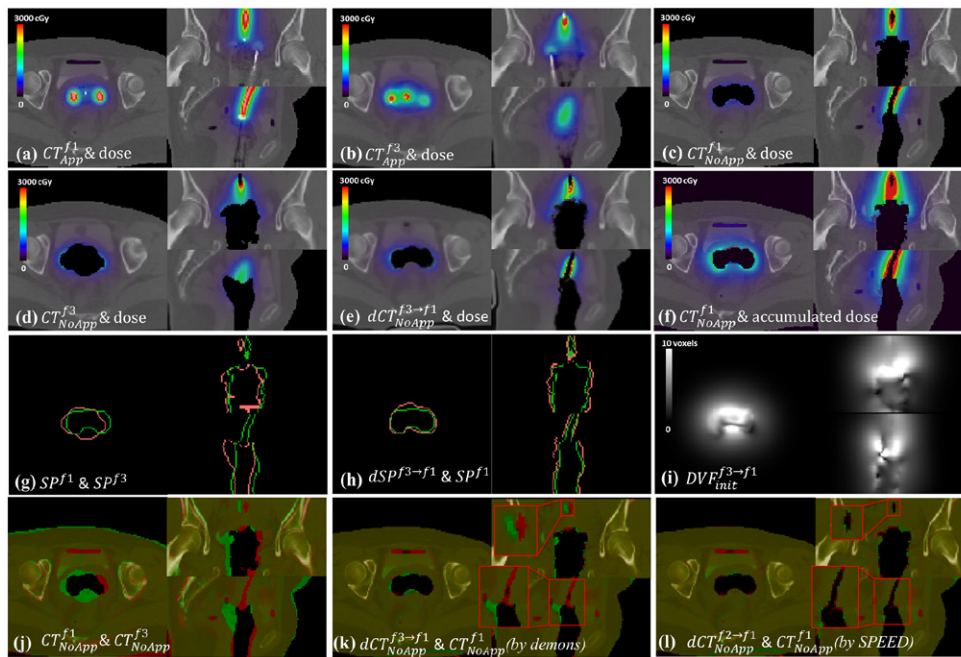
DIR results of HDR CT images with T and O applicator (Case1, i.e. fx1 of patient 1) and T and C applicator (Case 2, i.e. fx2 of patient 1). (a)  $CT_{App}^{f1}$  overlaid with dose; (b)  $CT_{App}^{f2}$  overlaid with dose; (c)  $CT_{NoApp}^{f1}$  overlaid with dose; (d)  $CT_{NoApp}^{f2}$  overlaid with dose; (e)  $dCT_{NoApp}^{f2 \rightarrow f1}$  overlaid with deformed dose; (f)  $CT_{NoApp}^{f1}$  overlaid with accumulated dose; (g)  $SP^{f1}$  (green) and  $SP^{f2}$  (red); (h)  $SP^{f1}$  (green) and  $dSP^{f2 \rightarrow f1}$  (red); (i)  $DVF_{init}^{f2 \rightarrow f1}$ ; (j)  $CT_{NoApp}^{f1}$  (green) and  $CT_{NoApp}^{f2}$  (red); (k)  $dCT_{NoApp}^{f2 \rightarrow f1}$  (red) by Demons and  $CT_{NoApp}^{f1}$  (green); (l)  $dCT_{NoApp}^{f2 \rightarrow f1}$  (red) by SPEED and  $CT_{NoApp}^{f1}$  (green).
